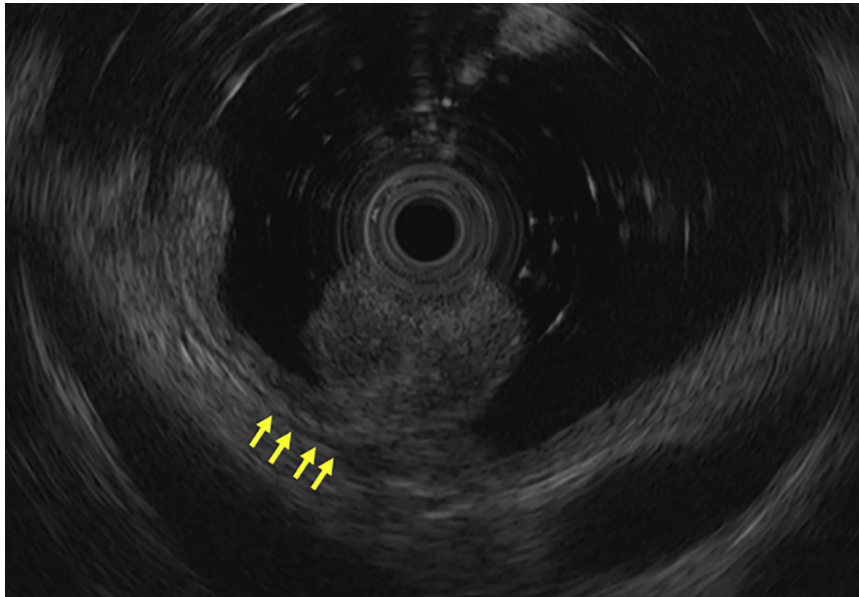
Endoscopic ultrasonography image of the lesions floating in the gelatinous liquid-filled lumen, whereas the muscular layer remained flat (arrows).
